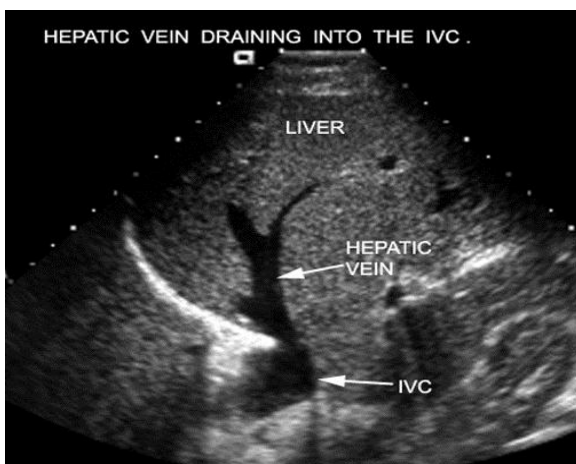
Normal ultrasound anatomy of hepatic veins
